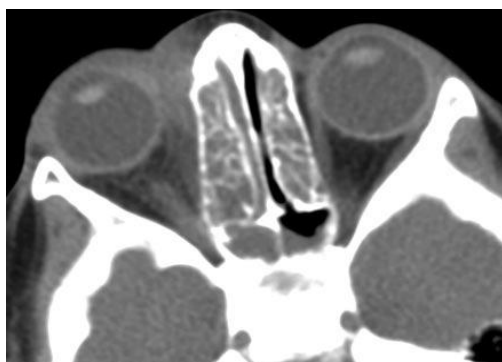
plain CT show increased attenuation with thickening of pre and post septalfat with opacification of ethmoid and sphenoid sinuses.
